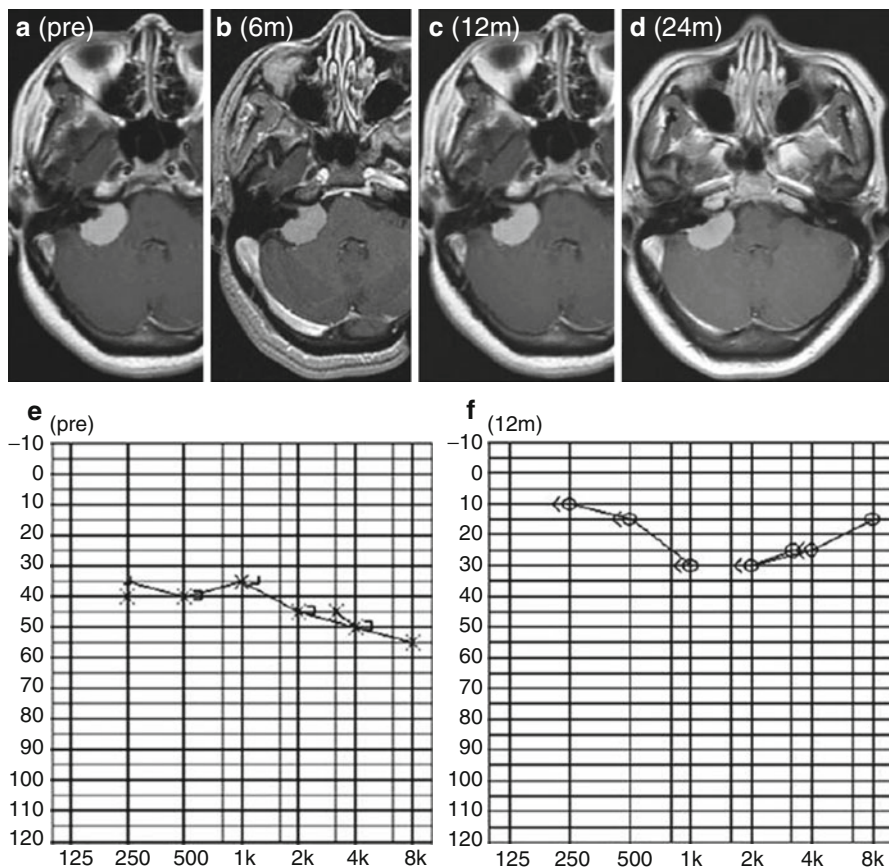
A magnetic resonance imaging of a 47-year-old patient with a meningioma extending into the right internal auditory canal. The tumour volume was 5.6 cm^3 , and the pure-tone audiometry (PTA) threshold and speech discrimination scores (SDS) were 40 dB and 12 %, respectively, corresponding to Gardner-Robertson (G-R) class 3 (a and e). Gamma Knife radiosurgery was performed. The maximal and mean cochlear radiation doses were 6.9 and 5.5 Gy, respectively. Six months later, the tumour volume was stable (b), and hearing function had improved to 30 dB of PTA and 80 % of SDS. Twelve months after radiosurgery, the tumour volume was 5.2 cm^3 , and the PTA threshold and SDS were 26 dB and 90 %, respectively (c and f). Twenty-four months after radiosurgery, the tumour had continued to shrink to 4.4 cm^3 (d) (Adapted from Kim et al. [58])
